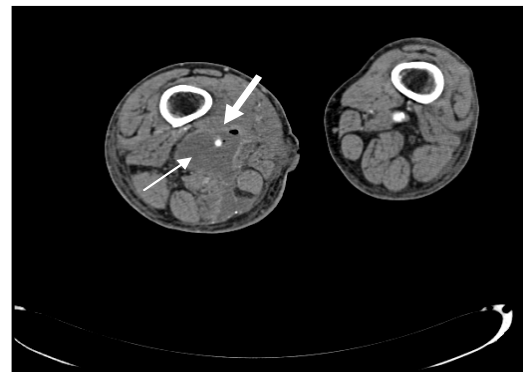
Computed Tomographic Angiography: abscess (thin arrow), venous graft (thick arrow).
